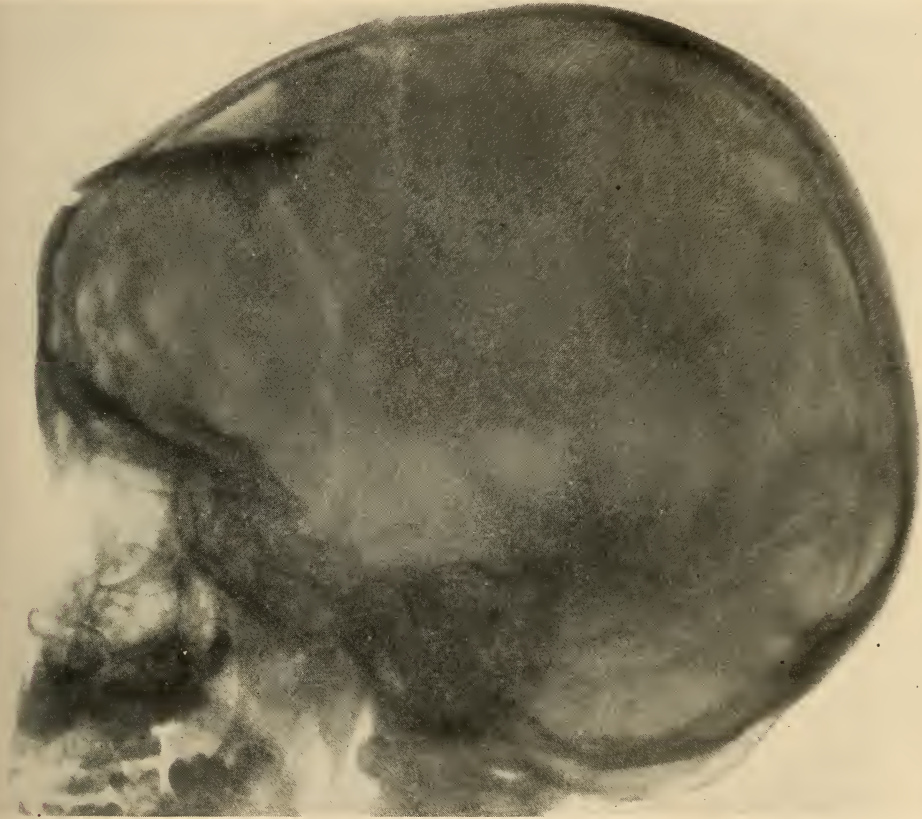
Harriet G. This patient of 43 years of age slipped and fell headlong from the front door-steps to the pavement—a distance of four feet; no loss of consciousness—"merely dazed," and that afternoon, she came to the out-patient department of the hospital by trolley-car on account of the "bump" over her forehead, which was gradually enlarging, and "a dull aching in the head." The hematoma was so tense and extensive that palpation and the routine bimanual examination, in the presence of her hair, were negative. She was permitted to return to her home and advised to "come for an X-ray picture in the morning." The huge depressed fracture of the vault, and the radiating linear fracture to the base, were most instructive, and fortunately in this patient an excellent result was obtained by performing a right subtemporal decompression, first to lower the general increased intracranial pressure of blood-tinged cerebrospinal fluid, and then the local depressed area of bone was removed; the underlying dura had been lacerated and even some cerebral tissue was lying at the site of the depression. The present condition of the patient, thirty-four months after the injury, is normal. The value, however, of an early röntgenogram in this type of patient is obvious.
